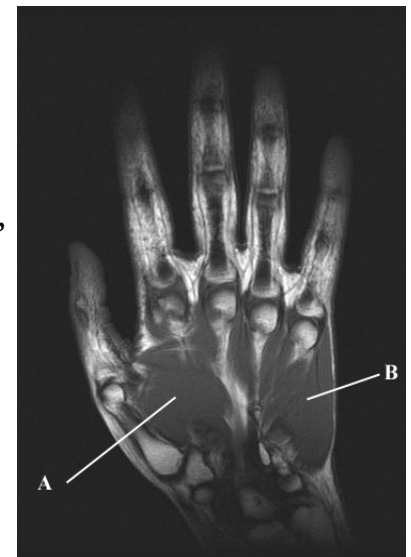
T1-weighted coronal of hand. A-muscles of thenar compartment, B-muscles of hypothenar compartment
